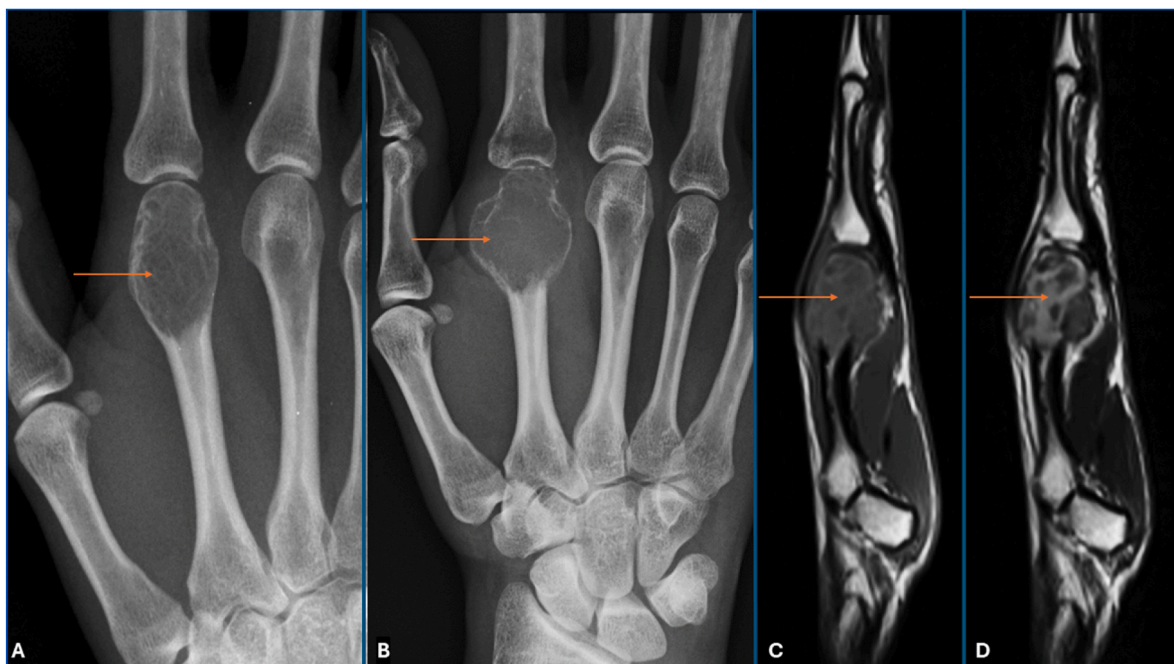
A–D: (A) Frontal radiograph of the hand showing the characteristic bubbly expansile osteolytic lesion in the distal 2nd metacarpal with subarticular extension; (B) progressive predominantly transverse fusiform expansive growth over a 3-month period, with cortical thinning plus irregular articular margin at the metacarpal articular head at the ulnar aspect; (C,D) Sagittal MRI sequences showing minimally heterogeneous T1 (C) and mixed intermediate-high T2 (D) signal soft tissue mass involving the distal third of the 2nd metacarpal with subarticular extension. Lesion remains bound by intact periosteum.
